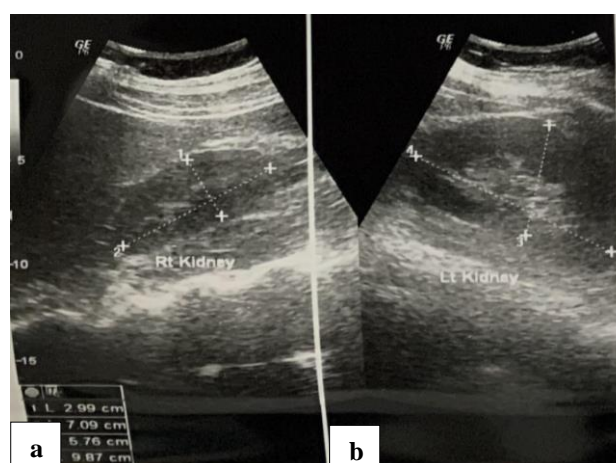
Ultrasonography of the kidneys (a) right kidney, and (b) left kidney.
